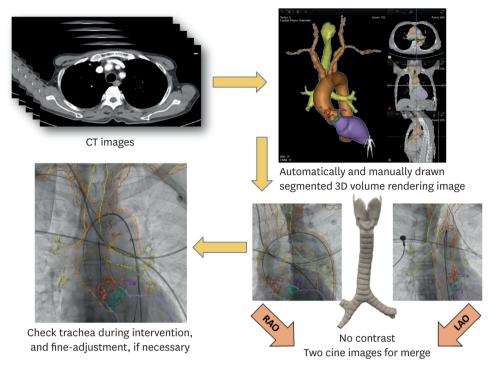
Procedural process of computed tomography merged imaging with the trachea as reference.
